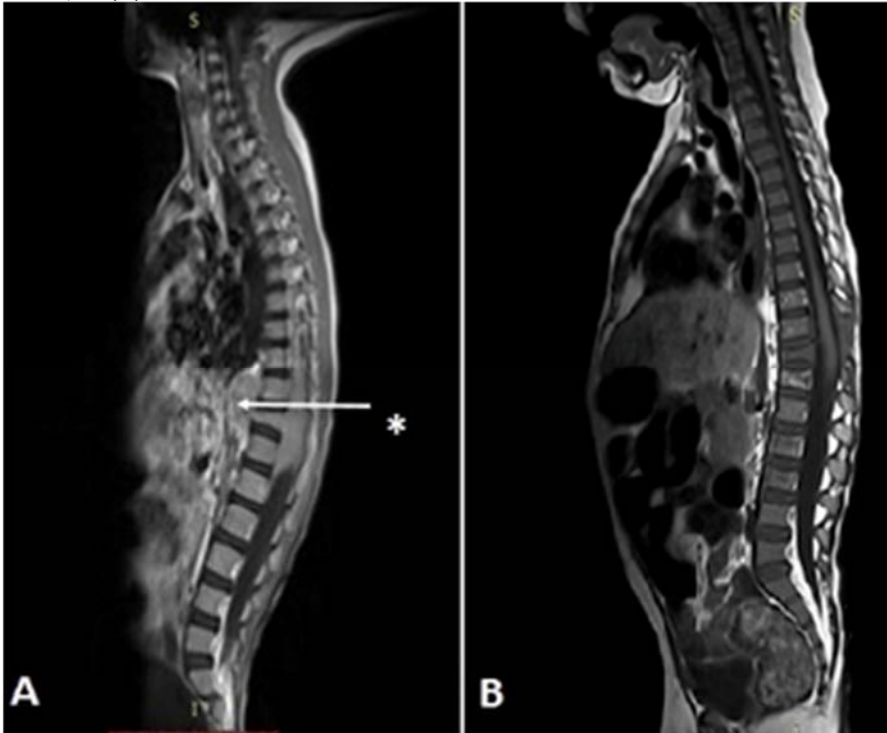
Sagittal T1-weighted MRI image showing an epidural, hypointense, craniocaudal 4.5 cm diameter mass compressing spinal cord at the level of D 10-12; Figure 1B: The image of the mass 1 month before completion of acute myeloid leukemia maintenance therapy
